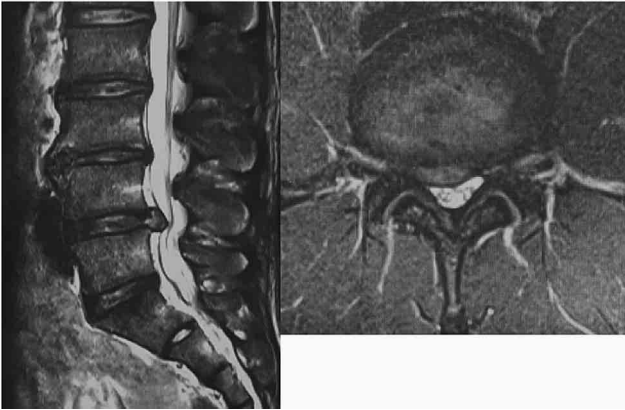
Magnetic resonance imaging (MRI) (T2-weighted sagittal and axial view at L4/5 level) before the first surgery. MRI showed the right paracentral disc protrusion at L4/5 level compressing the L5 root.
